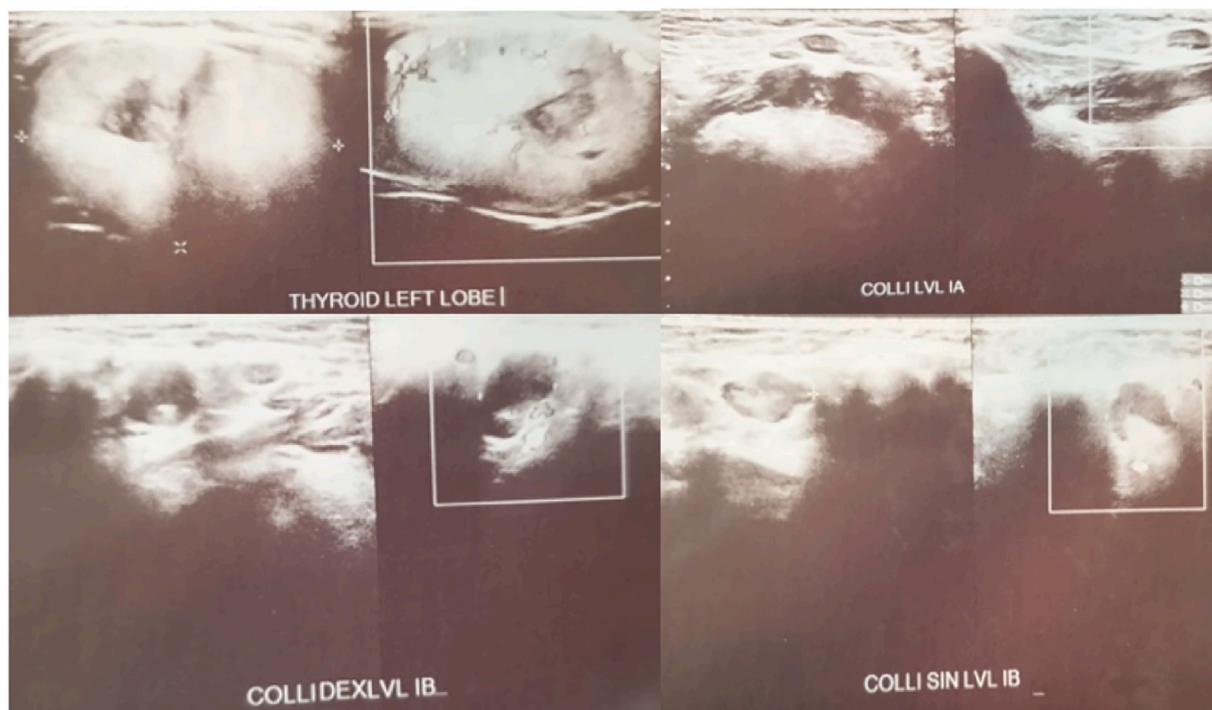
Initial thyroid ultrasonography showing hypoechoic lesion with cystic component and calcification on enlarged left lobe thyroid (TIRADS 4).
